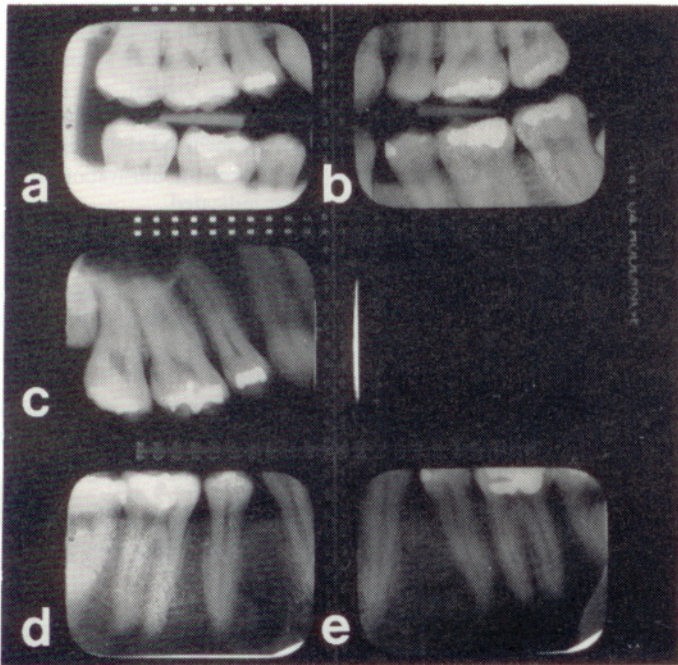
Radiographic comparison. Ante-mortems (a, b) and post-mortems (c, d, e).
